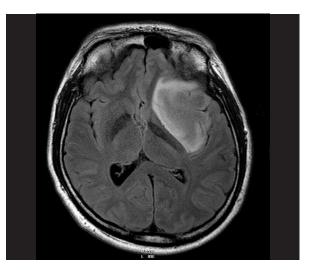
Patient FJ. T2-weighted FLAIR axial MRI image; left-sided, high intensity tumour clearly seen in the insula.Medial aspect of the tumour adjacent to the internal capsule
